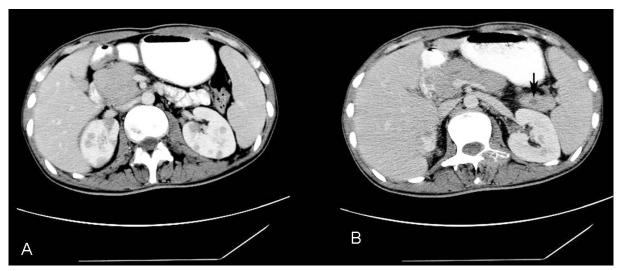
Contrast-enhanced CT scan reveals diffuse enlargement of pancreas with hypodens area within the tail (black arrow). Note bilateral multiple renal masses with homogenous attenuation, smooth borders and low contrast enhancement.
